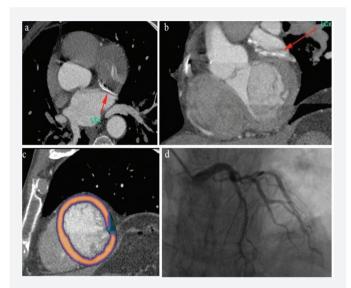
a, b) CCTA shows a calcified plaque and an irregularity in the LCX artery wall. The LCX artery also has motion artefacts. c) First-pass computed tomography myocardial perfusion imaging (CT-MPI) without stress revealed a perfusion defect in the left ventricular midanterolateral segment, d) Invasive angiography showed greater than 50% luminal narrowing in the LCX artery
